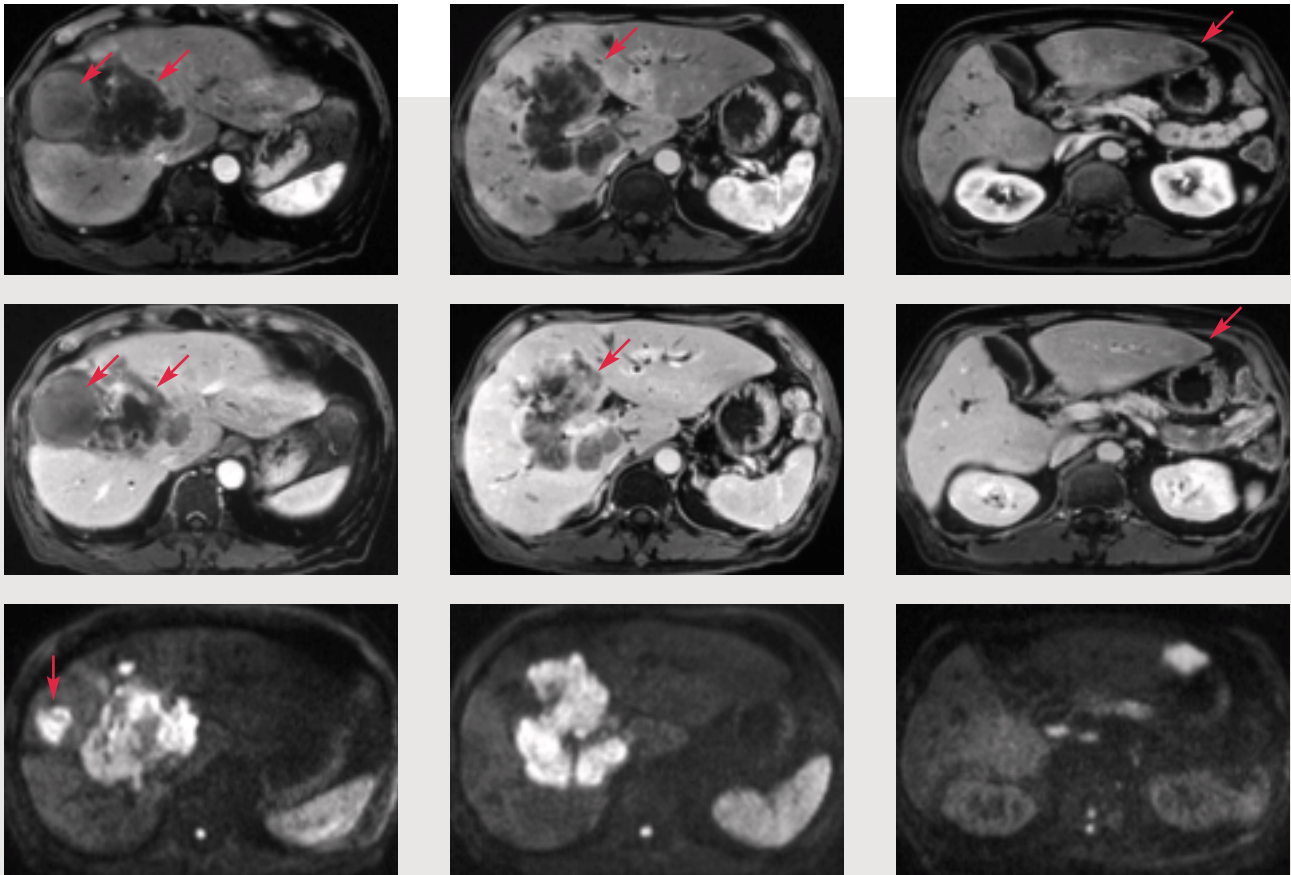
Compared to dynamic MRI with contrast medium, diffusion-weighted images show recurrent tumor after TAE (Trans Arterial Embolization) better.
